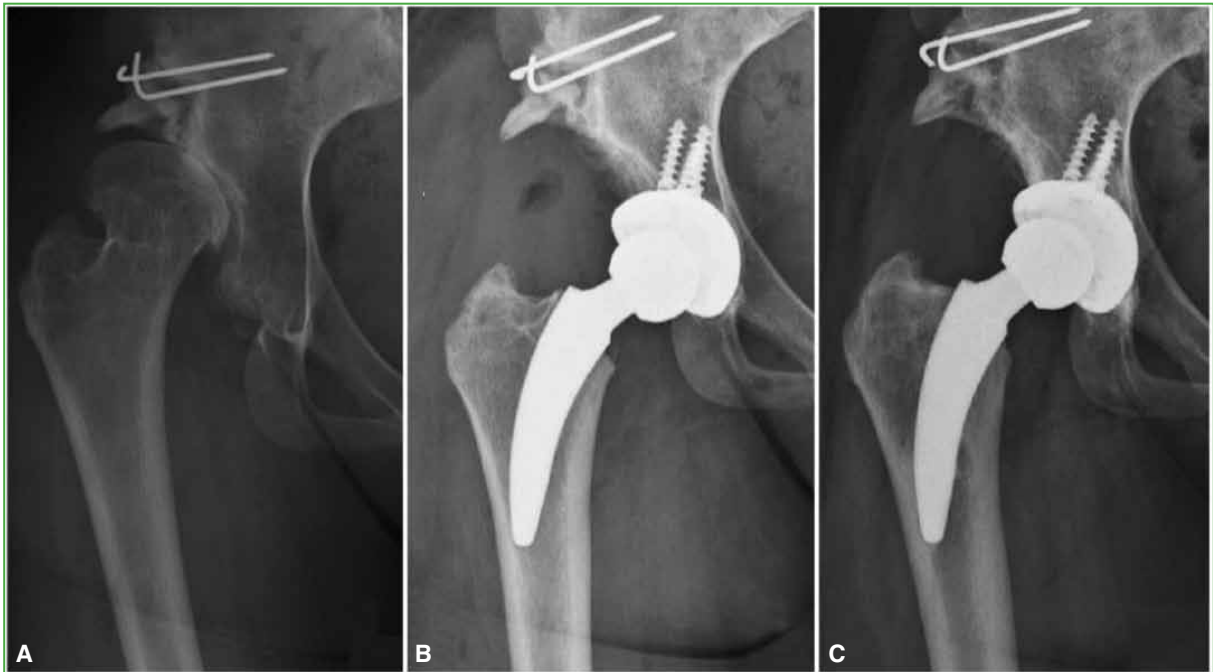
A. Anteroposterior radiograph of the right hip. A 25-year-old woman with dysplastic coxarthrosis Hartofilakidis grade B and coxa valga, and a history of pelvic osteotomy during childhood. B. Immediate postoperative anteroposterior radiograph of the patient's hip after femoral reconstruction with a partially neck-preserving MiniHip™ uncemented short stem. C. Anteroposterior radiograph of the patient's hip at 5-year follow-up showing stable stem fixation with no signs of implant loosening or subsidence.
